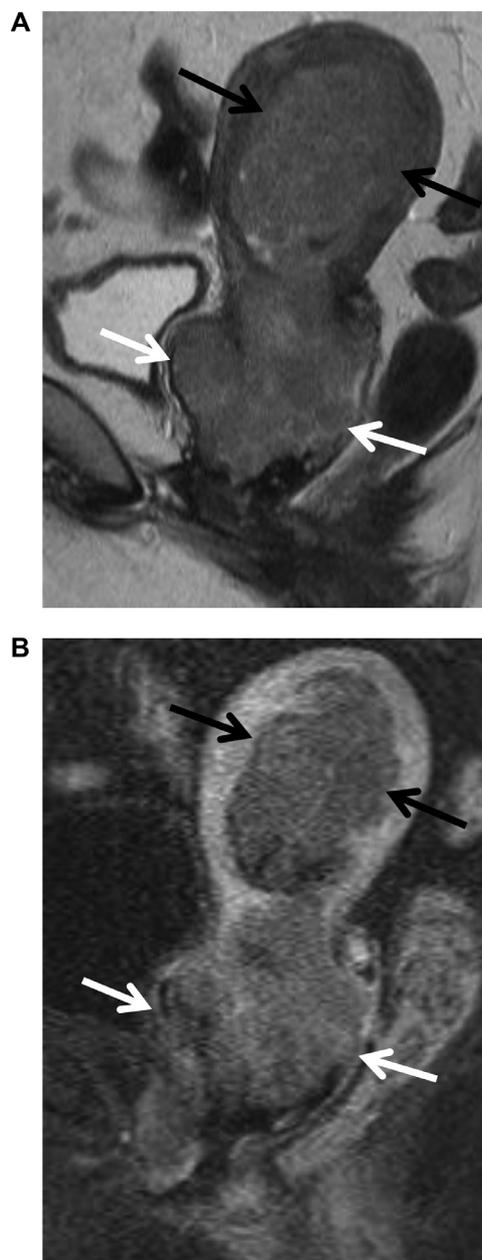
70-year-old female with endometrial cancer. (A) Sagittal T2-weighted image, and sagittal postcontrast T1-weighted image (B) show a large mass within the endometrial cavity (black arrow) that extends into the cervix measuring 10.8×4.0 cm involving the anterior and posterior vaginal walls (white arrows) and extending into the middle third of the vagina indicating stage IIIB. (Color version of figure is available online.)
